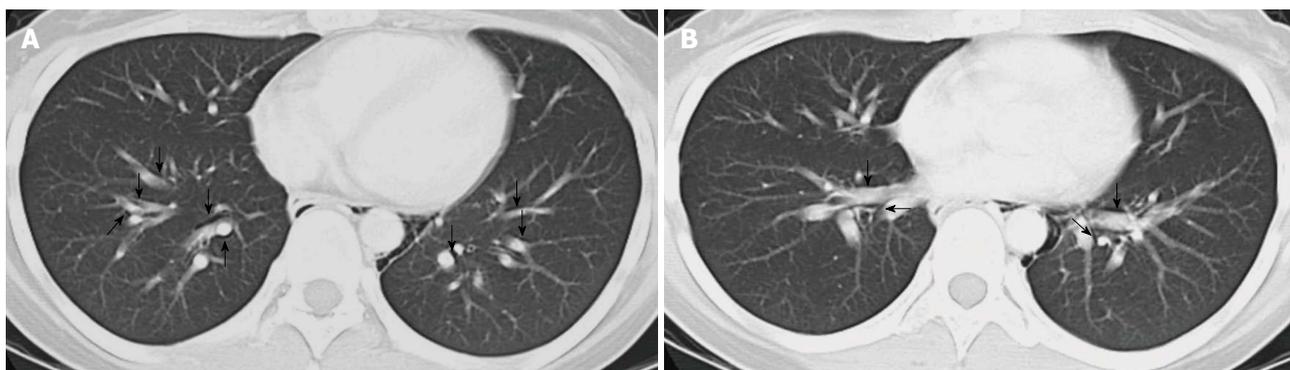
A 21-year-old woman with hypothyroidism and symptoms of cervical discomfort and tenderness. Multidetector-row computed tomography scan demonstrates air collection along the perivascular connective tissue, the Macklin effect (arrows), in the peripheral area (A) and in the perihilar area (B), and pneumomediastinum. Reprinted from ref. [5].
